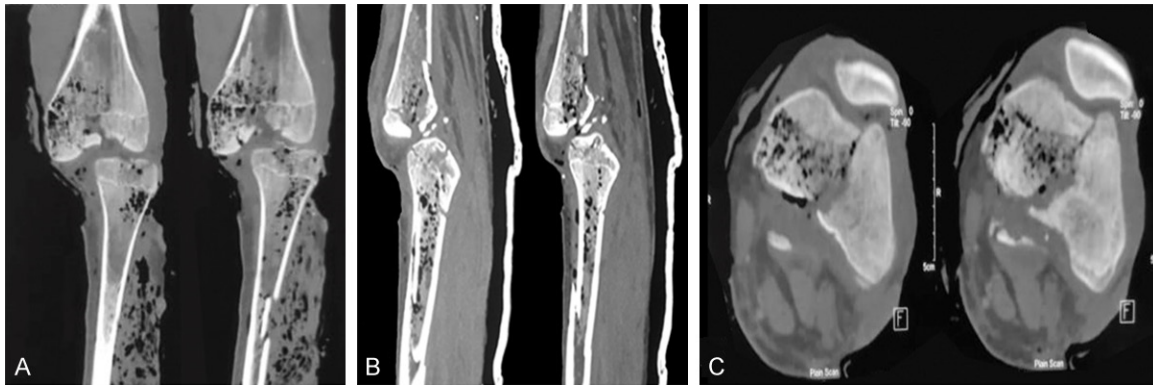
(A) Coronal, (B) Sagittal and (C) Axial sections - CT Scan image showing intraarticular distal femur and proximal tibia fracture with multiple gas shadows.
